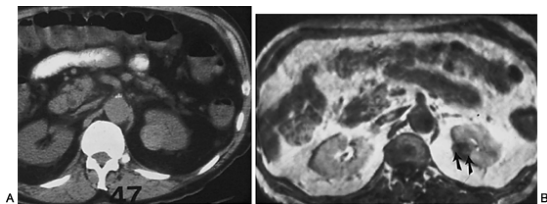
4. Magnetic resonance in the evaluation of indeterminate renal masses. A: This hemorrhagic cystic lesion in the left kidney measured 47 HU on computed tomography. Postcontrast scan showed no enhancement. B: Postcontrast gadolinium study demonstrates two small nodules of enhancement in the wall (arrows) of the lesion, which were foci of low-grade renal carcinoma.
